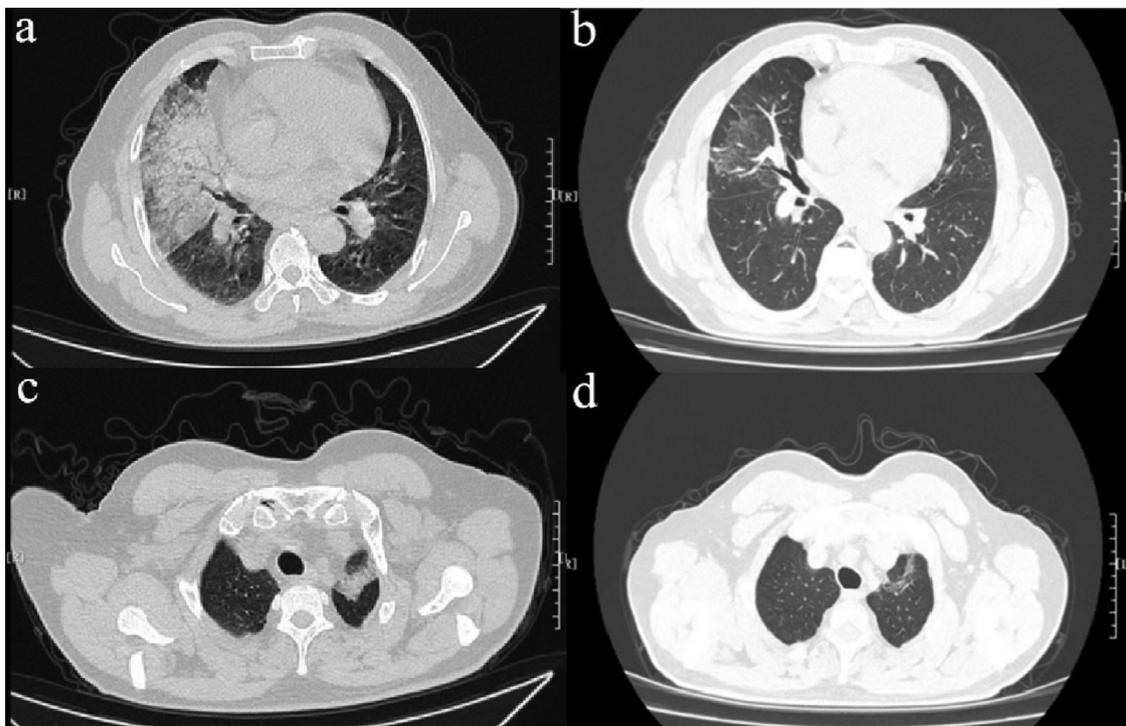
Images of chest computed tomography. (a, c) On the day of admission. (b, d) 28 days after discharge.
